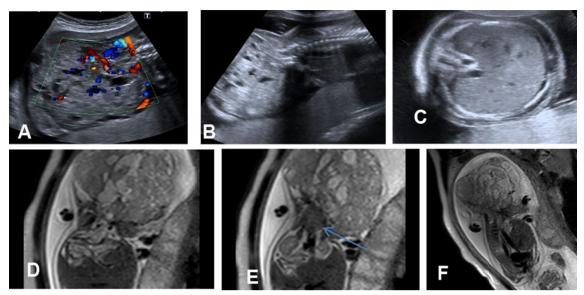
A 22-year-old pregnant female with late 1st trimester and another early 2nd trimester US revealing large fetal sacral mass lesion. Ultrasound findings: A, B Axial and coronal sections of the fetal lower back showing a large mixed solid and cystic mass lesion arising from the fetal sacral region with small intra-spinal extension and extensive neovascularization on Doppler interrogation. C Axial image at the level of fetal liver revealing marked skin thickening and subcutaneous edema. MRI findings: D, E, F axial, and sagittal T2WIs revealing the mixed solid and cystic sacral mass lesion with its smaller pelvic extension (arrowed) at the level of the fetal urinary bladder and actual size of intra-spinal extension (arrowed). Note associated diffuse fetal subcutaneous edema. Combined US and MRI Diagnosis: A large mixed solid and cystic highly vascular fetal sacrococcygeal teratoma with a smaller intra-pelvic and intra-spinal extension (stage IV) and complicated fetal hydrops. IUFD at 30 weeks
